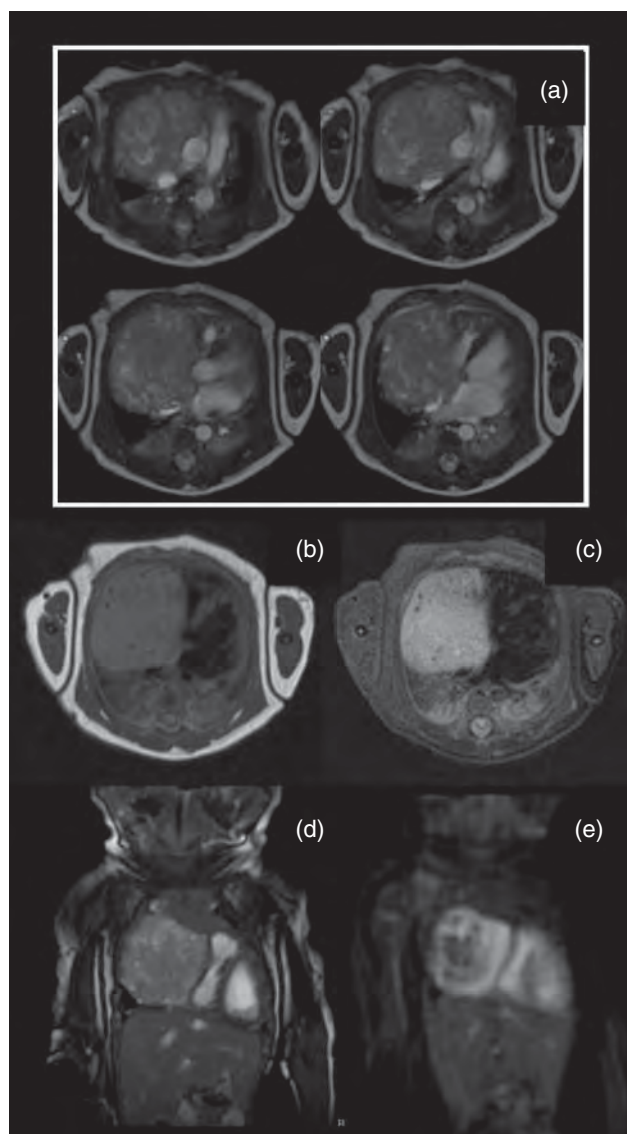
CMR images of a large right atrial hemangioma filling nearly the entire right hemithorax and compressing the right heart and superior vena cava with (a) an inhomogeneous appearance by cine imaging; (b) an isointense appearance with T1-weighted imaging; and (c) a hyperintense appearance secondary to its highly vascular nature by T2-weighted imaging with fat suppression. (d) The tumor compresses the right ventricle by cine imaging in a coronal plane, and (e) it demonstrates intense perfusion with a central dark region, consistent with regions of high vascularity and intervening cystic tissue.
